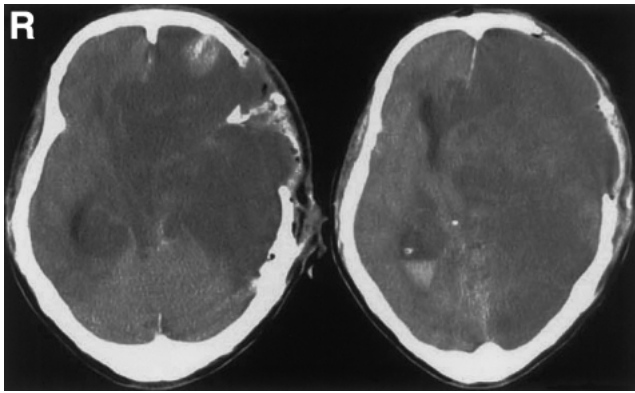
Computed tomography scans 8 hours after the craniotomy demonstrating severe brain swelling with shift of the whole left cerebral hemisphere.
